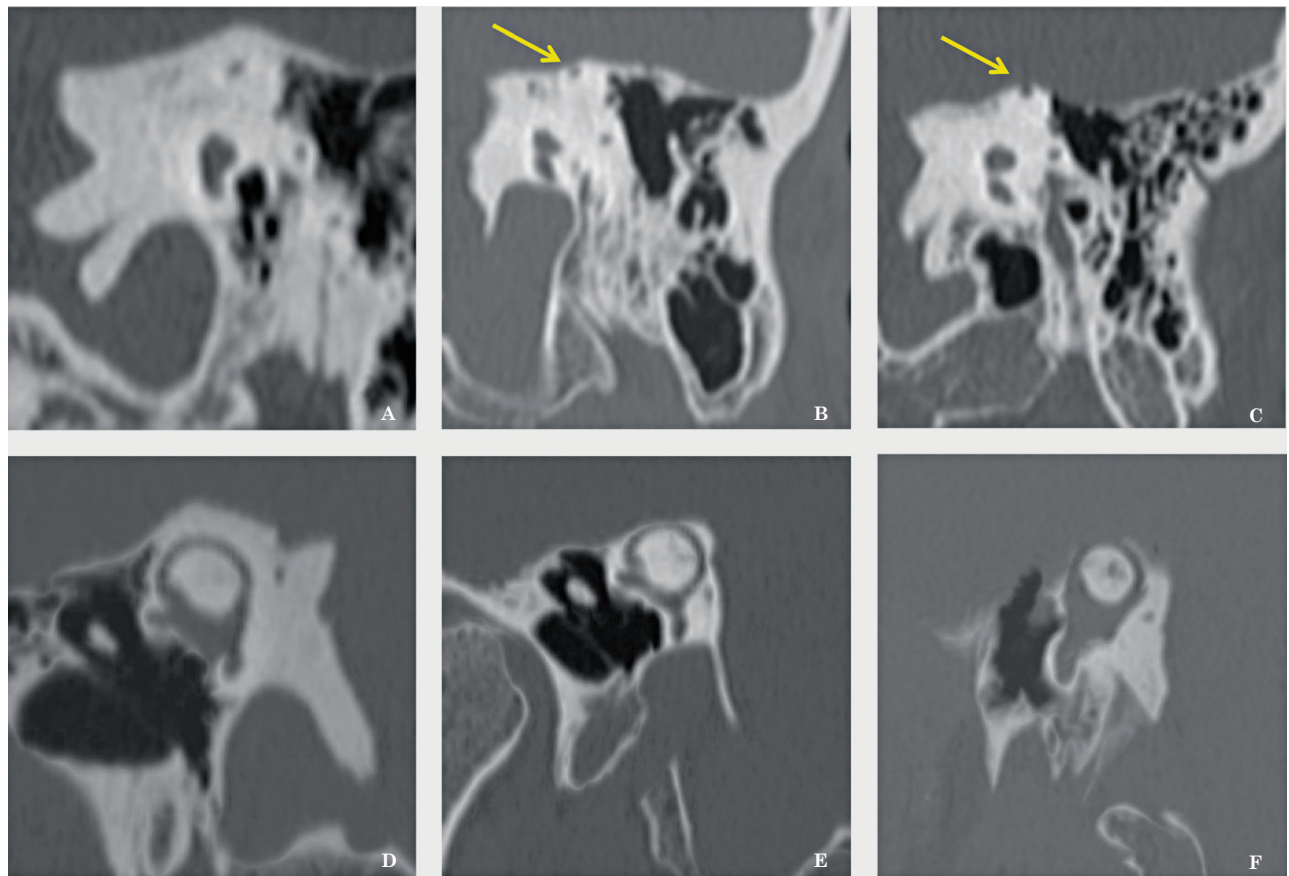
Coronal CT images and min-IP images reconstructed on semicircular canals with thickness evaluation. A, B) Normal condition. C, D) Thinning (arrow in C) of the osseous capsule covering the superior semicircular canal. E, F) Dehiscence (arrow in E) of the osseous capsule covering the superior semicircular canal.
